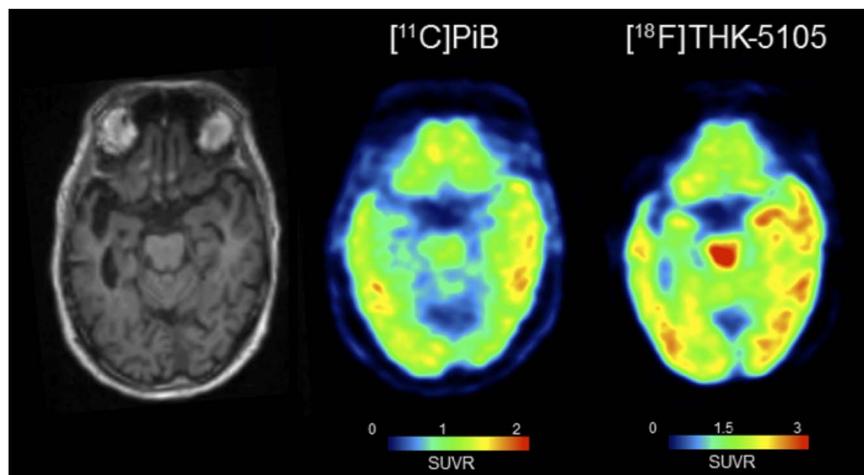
Co-registered MRI, $[^{11}\text{C}]\text{PiB}$ and $[^{18}\text{F}]\text{THK-5105}$ images in a patient with Alzheimer's disease (AD). Figure depicts a structural MRI (left), $[^{11}\text{C}]\text{PiB}$ (center), and $[^{18}\text{F}]\text{THK-5105}$ PET images (right), from a patient with dementia resulting from AD (images courtesy of Profs. V. Villemagne and N. Okamura). Images were co-registered in the plane encompassing the temporal lobe, hippocampus, orbitofrontal cortex, amygdala, midbrain, and cerebellum. MRI shows bilateral hippocampal atrophy (right > left). $[^{11}\text{C}]\text{PiB}$ images show high uptake (yellow-red spots) in the temporal neocortex. $[^{18}\text{F}]\text{THK-5105}$ shows high uptake (yellow-red spots) in the mesial temporal as well as the temporal neocortex. The high $[^{18}\text{F}]\text{THK-5105}$ uptake in the midbrain possibly represents high nonspecific binding, a finding that would prove consistent with the vast literature addressing AD imaging and neuropathology. Of note, low uptake of both $[^{11}\text{C}]\text{PiB}$ and $[^{18}\text{F}]\text{THK-5105}$ can be seen in the cerebellum, an important finding because the cerebellum serves as the reference region when determining the standardized uptake value ratio (SUVR). A semiquantitative approach, SUVR is defined as the ratio of cortical to reference region radioactivity (i.e. tracer retention). In the case of $[^{11}\text{C}]\text{PiB}$ and $[^{18}\text{F}]\text{THK-5105}$ here shown, the reference regions are the cerebellum (vermis excluded) and the pons, respectively.
